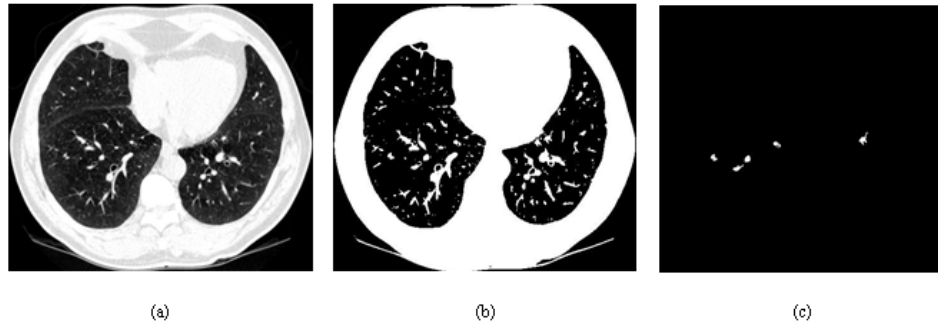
(a) CT image; (b) binary image; (c) ROIs after 2D preprocessing.
